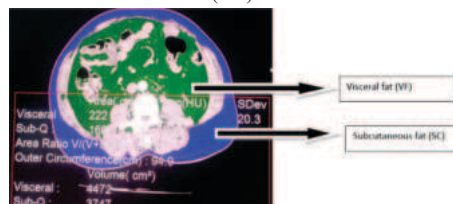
CT abdomen showing visceral fat (VF), subcutaneous fat (SC), total fat (TF) area and their ratios in a patient with CD:
